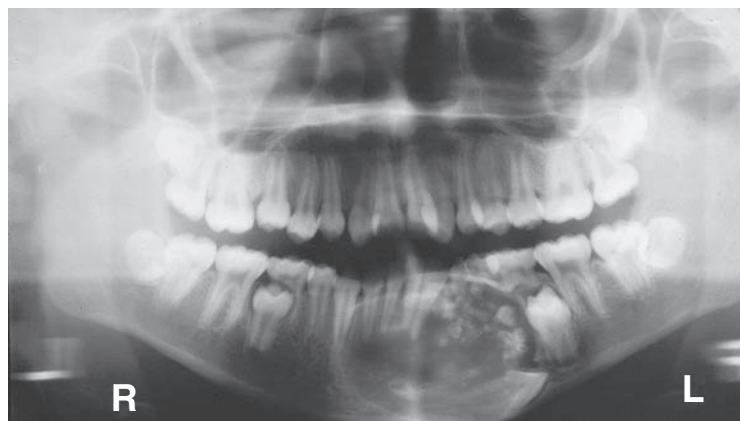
Radiograph of a calcifying odontogenic cyst with well-demarcated margins extending from the right to the left premolar regions of the mandible. Numerous calcifications are present, some suggestive of small denticles.
